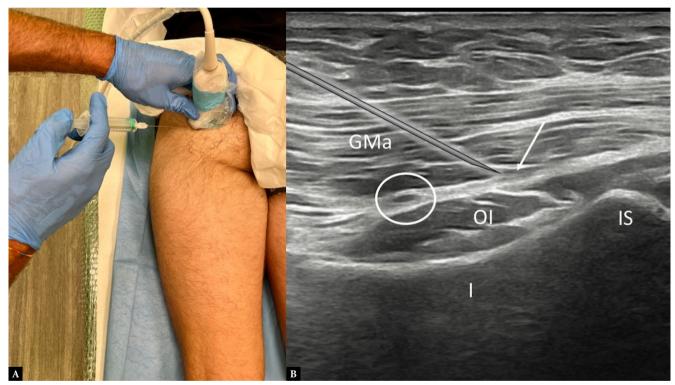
Ultrasound-guided injection of the pudendal nerve. A. The patient is prone, and the linear transducer is placed in oblique position at the level of the ischiatic spine. B. The pudendal nerve (arrow) is identified medial to the pudendal artery (within the circle) between the gluteus maximus muscle (GMa) and the obturator internus muscle (OI). Once identified, the needle can be advanced with in-plane lateral-to-medial approach. I – ischial bone; IS – ischial spine
